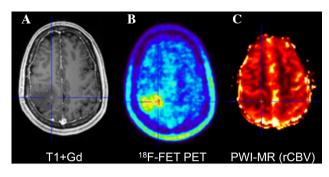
Hybrid PET/MRI of a patient with an oligoastrocytoma WHO grade III. Contrast-enhanced T1-weighted MR imaging (A) shows a large mass in the right parietal lobe showing no contrast enhancement. FET PET (B) detects a local maximum in the paramedian part of the tumour which is not obvious in the rCBV map (C)
